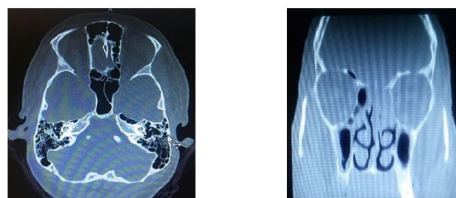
(Left): An axial bone window non-contrast CT scan of PNS depicting a soft tissue density mass filling the ethmoid sinuses.
